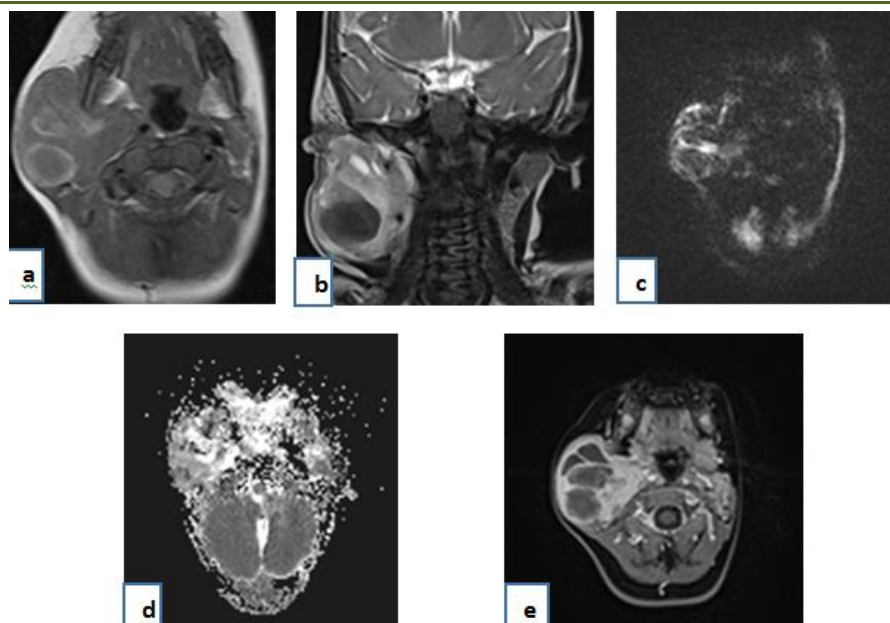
MRI showing a heterogeneous signal on T1 (a) and T2 weighted (b), restricted diffusion (c-d), heterogeneously enhanced after injection of gadolinium delimiting large areas of necrosis(e).
